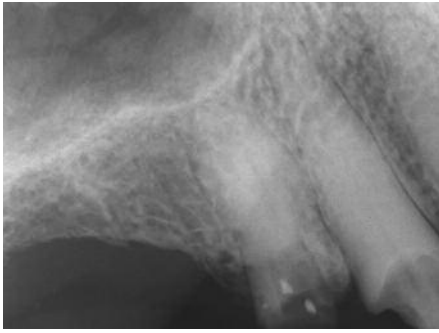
My 1983 preoperative radiographic reveals coronally broken down and endodontically involved teeth UR3 and UR4
